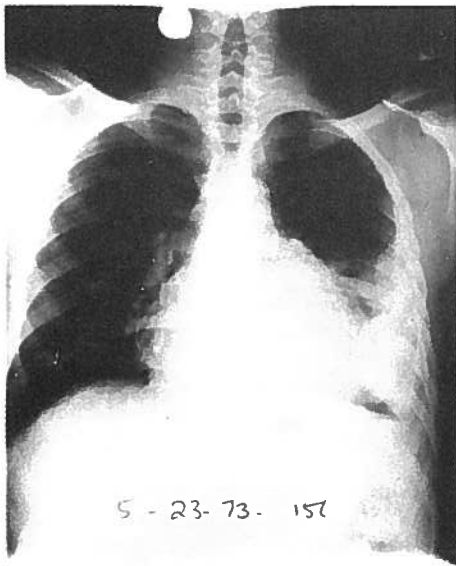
AP and lateral chest roentgenograms of a teenage boy shot in the left axilla. The missile has traversed the mediastinum. Esophagram failed to demonstrate any injury to the esophagus. There was no mediastinal emphysema. Because of the location of the bullet, he was explored through a right thoracotomy. The bullet was lodged between the right main stem bronchus and the right main pulmonary artery. It had penetrated the posterior wall of the right main pulmonary artery, which was repaired. The left pleural hematoma eventually resorbed.
